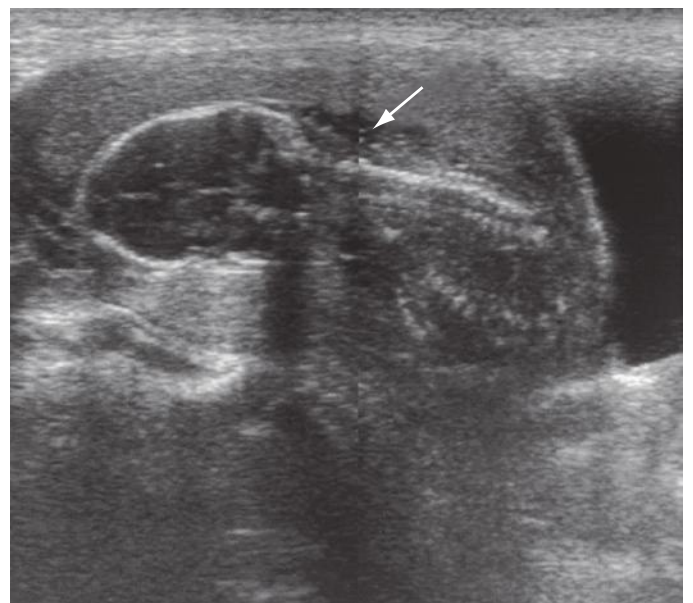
Sonogram of a fetus with renal agenesis. Virtually no amniotic fluid is seen. The fetus is “crowded” within the uterus. The only relatively anechoic space is occupied by the umbilical cord (arrow).
